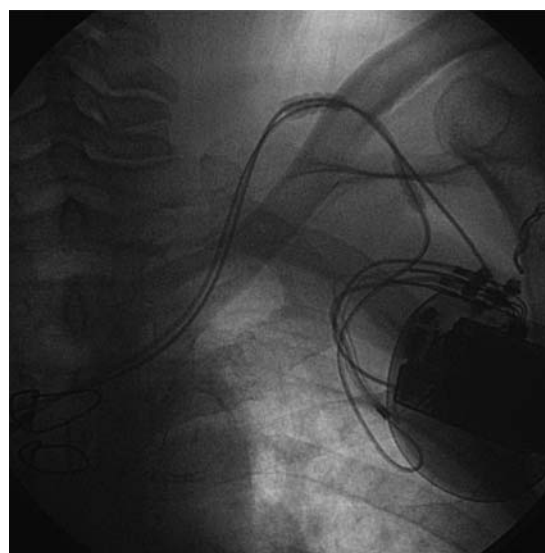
Postoperative chest radiograph (Patient 4). The leads are secured by suture to the subcutaneous tissue of the fossa supraclavicularis major using a protective sleeve; they are subcutaneously tunnelled over the clavicle and connected to the generator in the prepectoral pocket.
